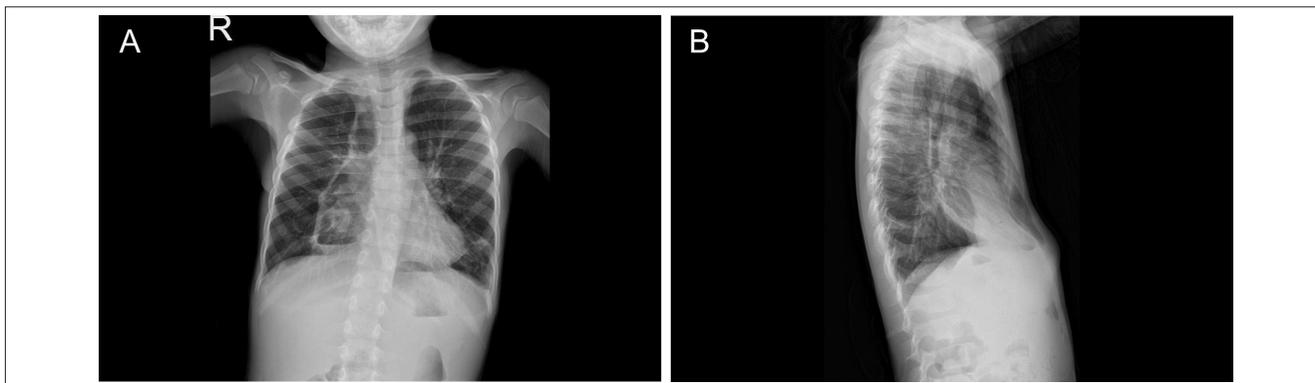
a,b. Chest radiograph images of the patient who underwent colon interposition.
